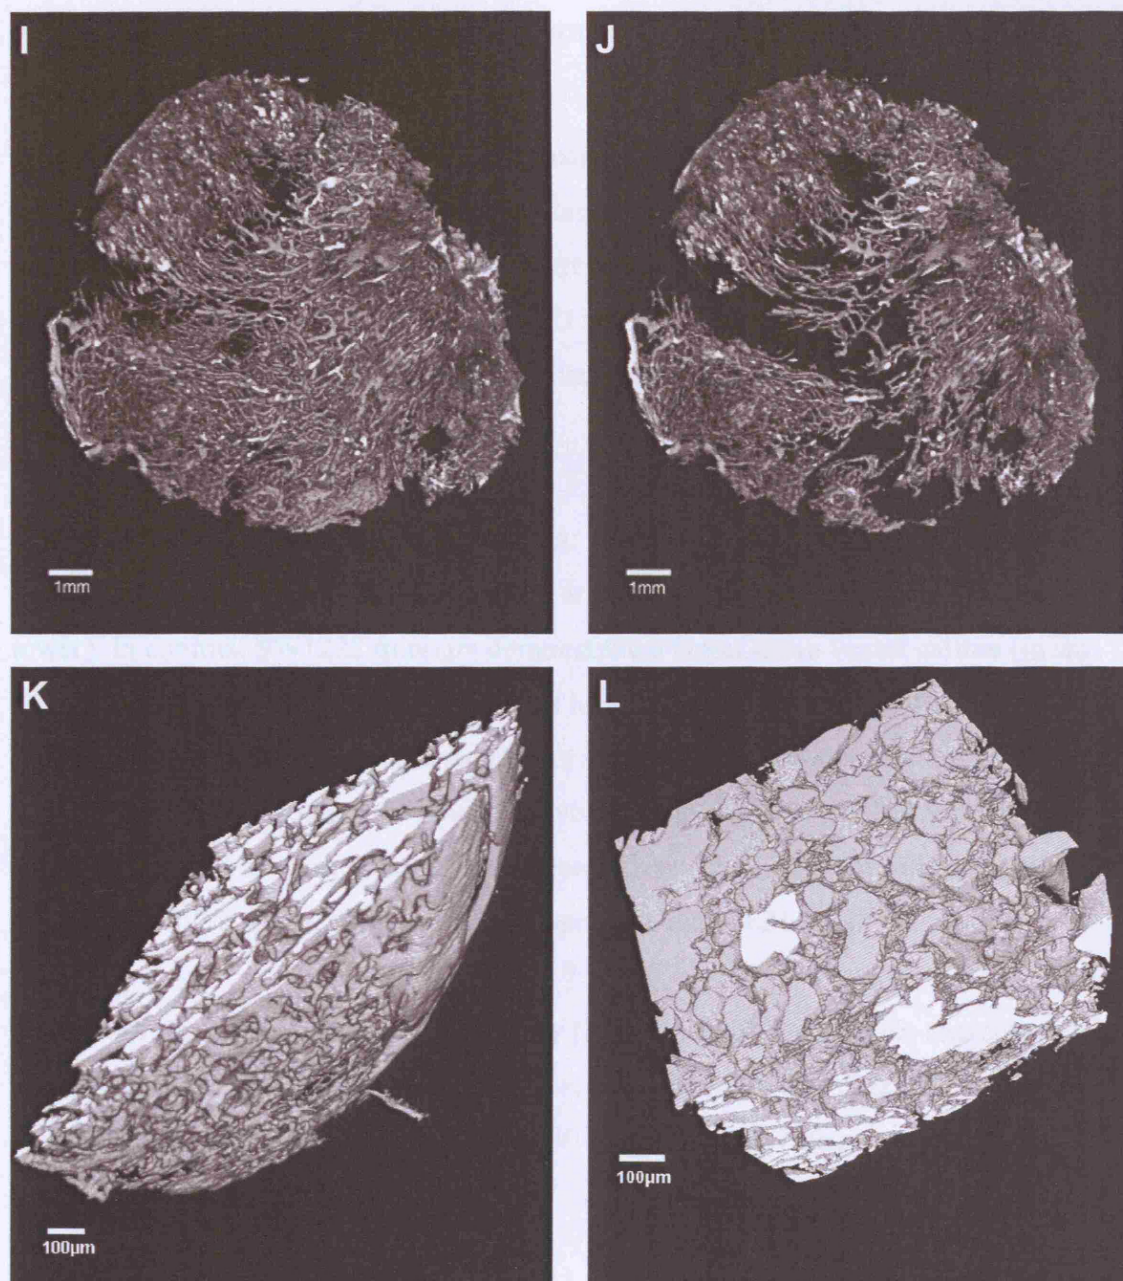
3D rendering of corrosion cast microcomputed tomography A) normal mucosa, B) normal mucosa cut-away, C) Adenoma, D) Adenoma cut-away, E) Adenocarcinoma, F) Adenocarcinoma cut-away, G) LS147T xenograft whole digitised cast volume rendering, H) LS147T xenograft cut-away showing large avascular regions, I) SW1222 whole digitised cast volume rendering, J) SW1222 xenograft cut-away generated by virtual sectioning, (K) high resolution SW1222 and (L) a cropped volume of the high resolution SW1222 volume from the edge of the xenograft, this region is almost completely composed of vascular tissue. (G/H) and (I/J) are low resolution renderings of whole xenografts demonstrate the power of X-ray micro-computed tomography to determine vascular systems in whole tumours. These datasets however were not used in the morphometry study which was restricted to the use of high resolution scans.
